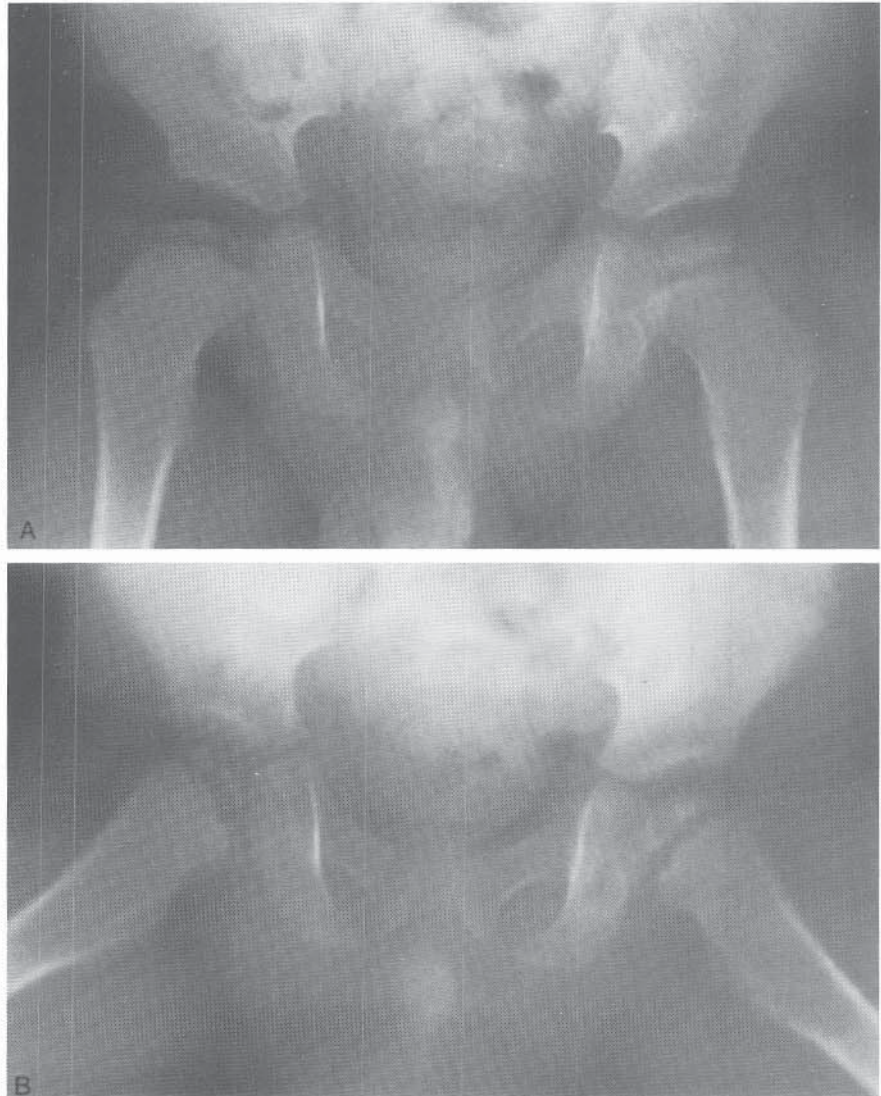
Epiphyseal changes in hypothyroidism that may be mistaken for Legg-Calvé-Perthes disease. A, AP and B, frog-leg lateral radiographs of both hips of a 4-year-old boy with hypothyroidism. Note the delay in and irregularity of ossification of the femoral heads.
